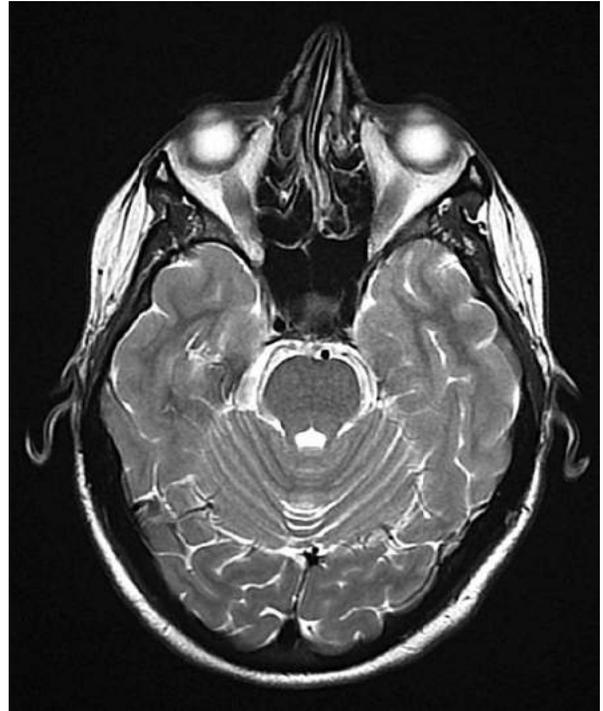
MRI of the head showing a right temporal AVM with the nidus size approximately 2 cm
